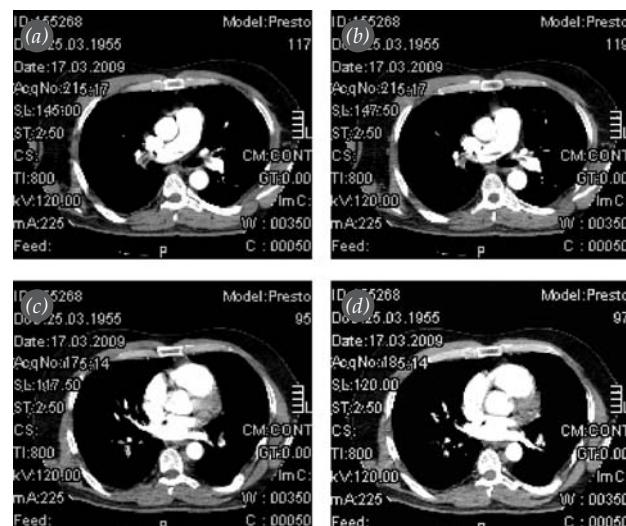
Pulmonary CT angiography. In images 117 (a) and 119 (b), a massive embolus is seen in bilateral main pulmonary arteries. In images 95 (c) and 97 (d), a massive embolus is seen in the segmental arteries of the inferior lobes.
